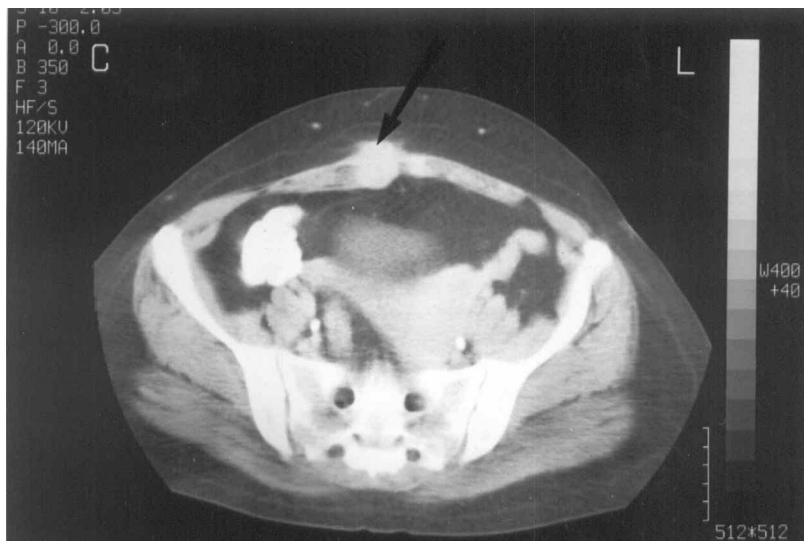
Computed tomography scan of abdominal wall endometrioma (arrow).
